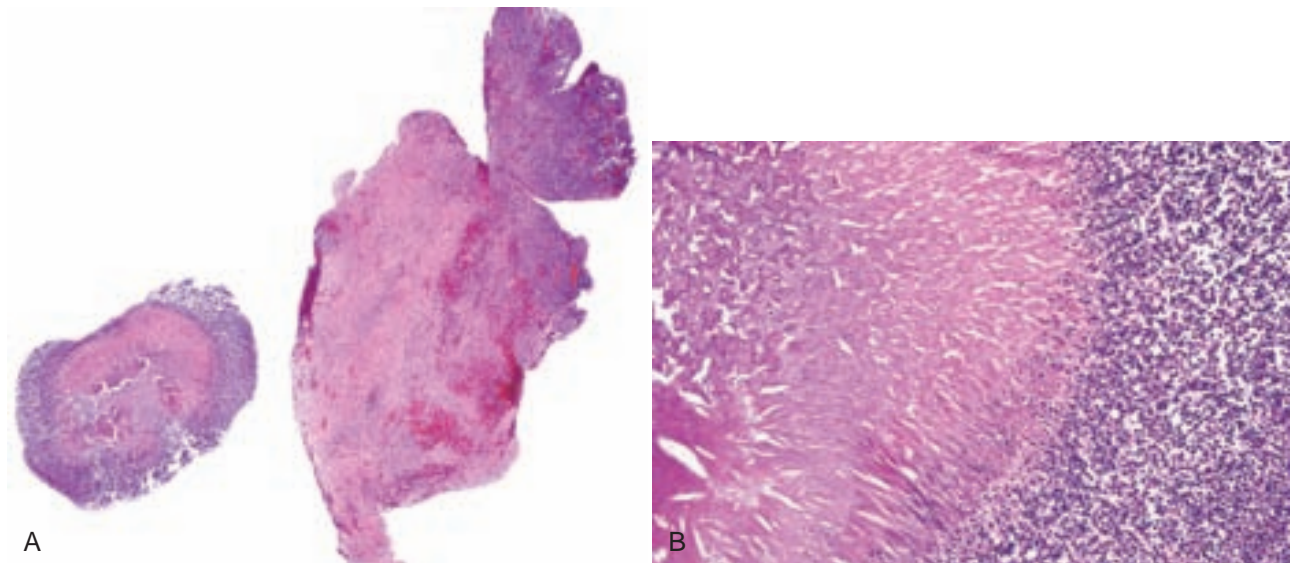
Periapical actinomycosis. A, Granulation tissue and sulfur granule. B, Sulfur granule with peripheral eosinophilic radiating morphology and suppuration.
